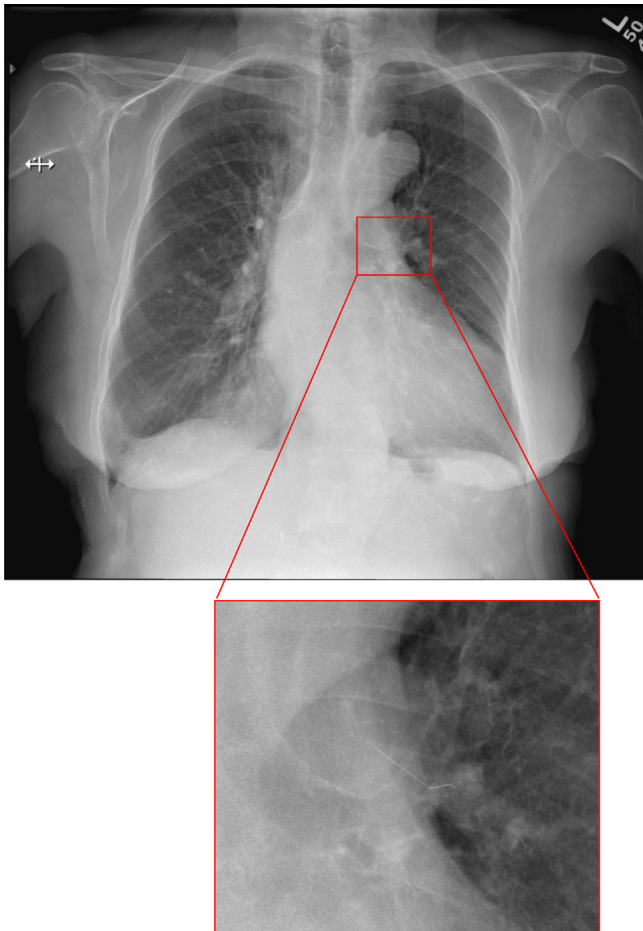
Chest x-ray showing a foreign linear structure at the left upper part of the lung (structure better seen in the magnified image on the right).
